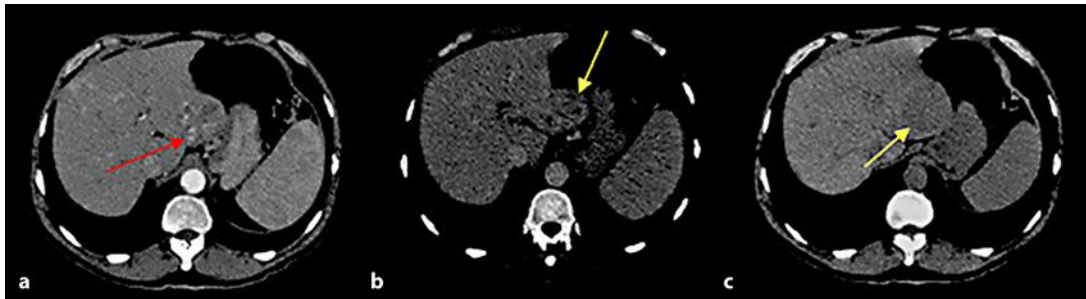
Triple-phase CT scan. a Arterial phase of contrast enhancement showing neovascularity (red arrow) in a low-density hepatic mass in the left lobe. b, c Portal and excretory phases are shown, respectively; there is a hypodensity (yellow arrow) in the same topography. These findings are commonly referred to by radiologists as “arterial enhancement with washout” and they have high accuracy in the diagnosis of HCC (sensitivity of 83% and specificity of 91% [39]).
